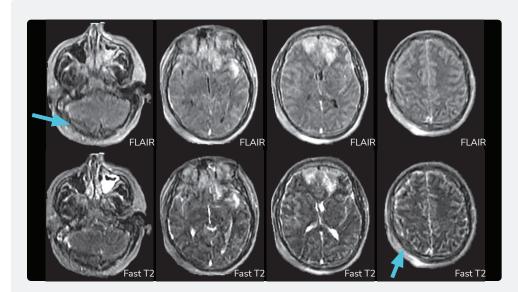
Initial pMRI findings on day four. Axial FLAIR and Fast T2 images show hypointense right parietal and right suboccipital epidural hematomas (arrows). Bifrontal hemorrhagic contusions are also evident.
